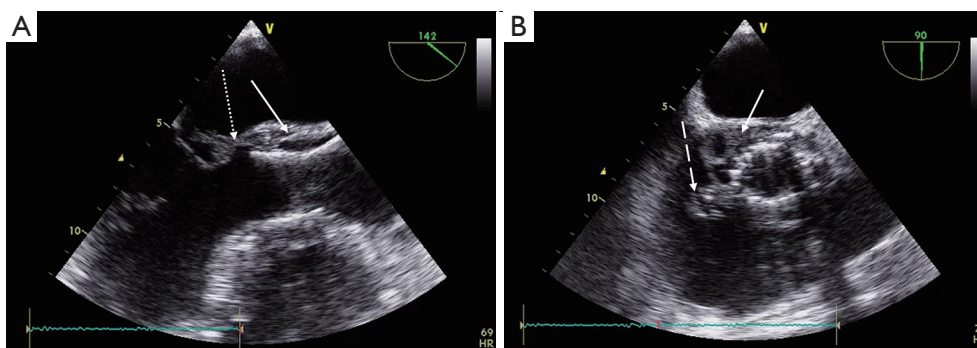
Transoesophageal echocardiography in a long-axis (A) and short-axis view (B) showing massive endocarditis five months after implantation of a CoreValve prosthesis caused by *Enterococcus faecalis*. Not only the perivalvular space (white solid arrow in A and B) is affected but also perforation and vegetation at the anterior mitral valve leaflet (white dotted arrow in A) and vegetation at the septal tricuspid valve leaflet (white dashed arrow in B) are evident.
